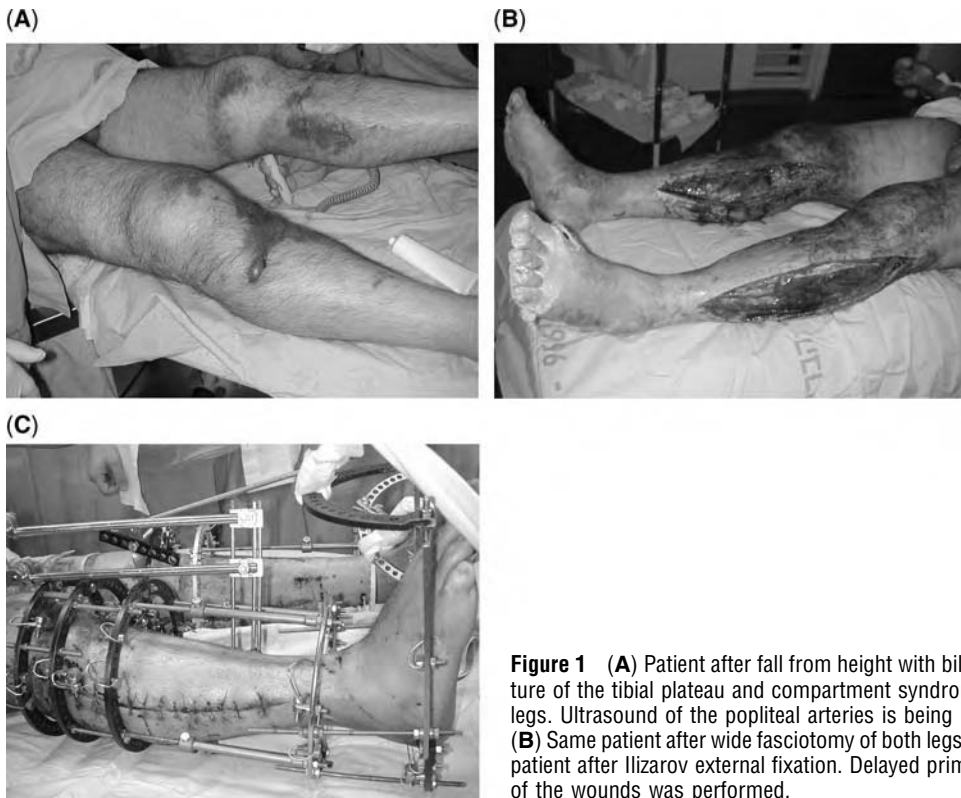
(A) Patient after fall from height with bilateral fracture of the tibial plateau and compartment syndrome of both legs. Ultrasound of the popliteal arteries is being performed. (B) Same patient after wide fasciotomy of both legs. (C) Same patient after Ilizarov external fixation. Delayed primary suture of the wounds was performed.
